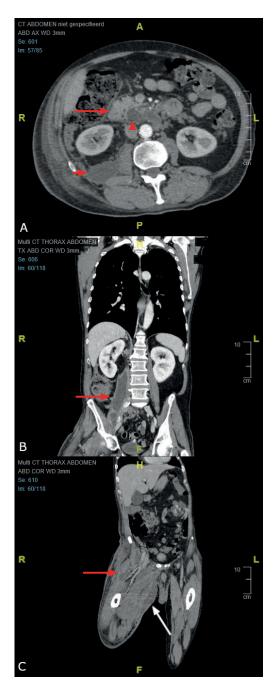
A. CT scan showing (axial) necrotic fluid collection (arrowhead) next to the head of pancreas (long arrow). B. CT scan (coronal) showing retroperitoneal abscess bulging towards the right iliopsoas muscle (Arrow). C. CT scan (coronal) of right upper leg showing the intramuscular collections below the rectus femoris muscle (red arrow) and the right groin (white arrow).
